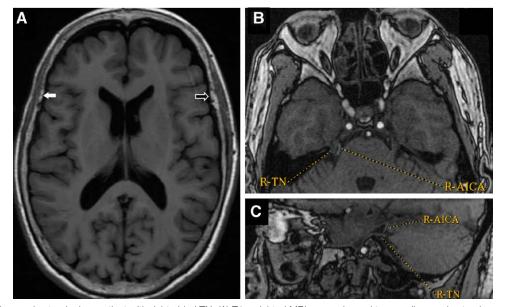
Temporalis muscle atrophy in a patient with right-sided TN. (A) T1-weighted MRI scans showed temporalis muscle atrophy on the right side (white arrow) in comparison to the normal temporalis muscle on the left side (black arrow). (B and C) The axial and sagittal scans of magnetic resonance tomography angiography (MRTA) showed that the right TN was slender. The right anterior inferior cerebellar artery was closely related to the right TN, and the space between blood vessels and nerves was smaller than the diameter of blood vessels.
